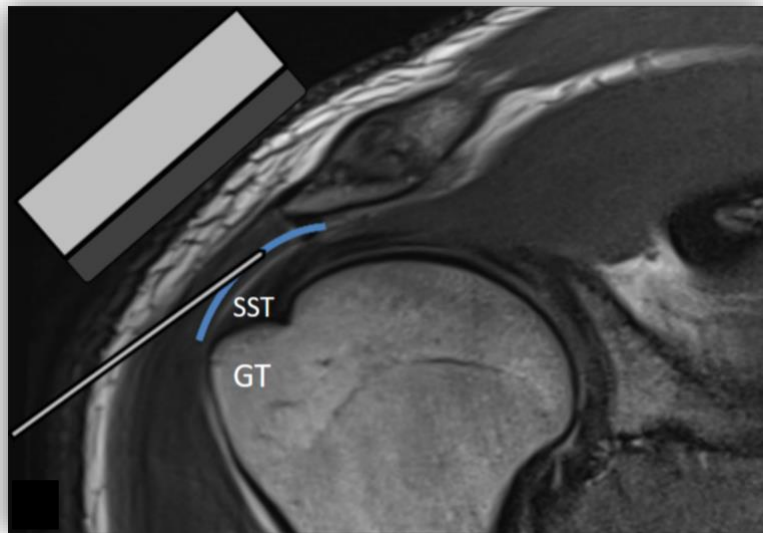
Coronal-oblique T1-weighted MR image demonstrating proper US transducer position and trajectory of the needle into the SASD bursa (blue line).
